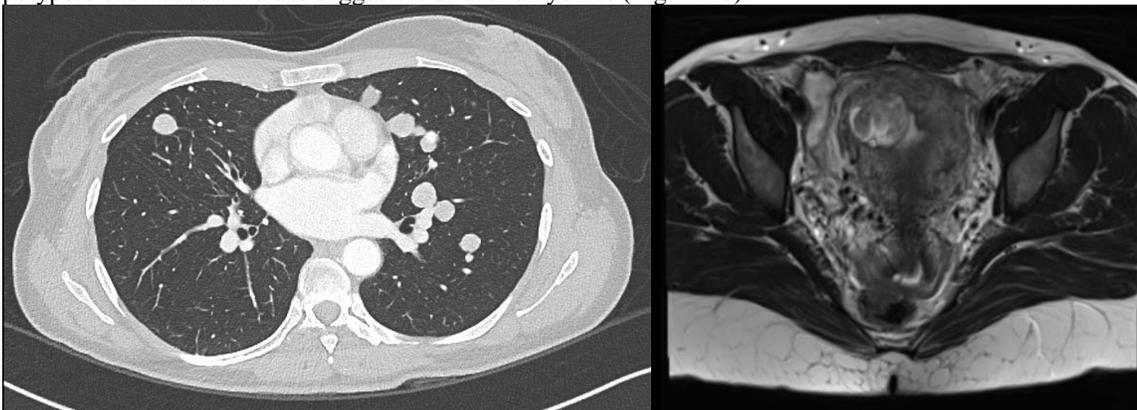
a) Follow up CT scan chest shows progression of bilateral lung nodules. b) MRI scan pelvis shows uterine polypoid adenomyosis.
